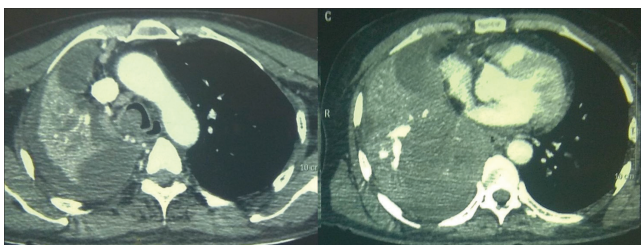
Chest CT scan showing right lung mass with areas of calcification and tracheal extension
